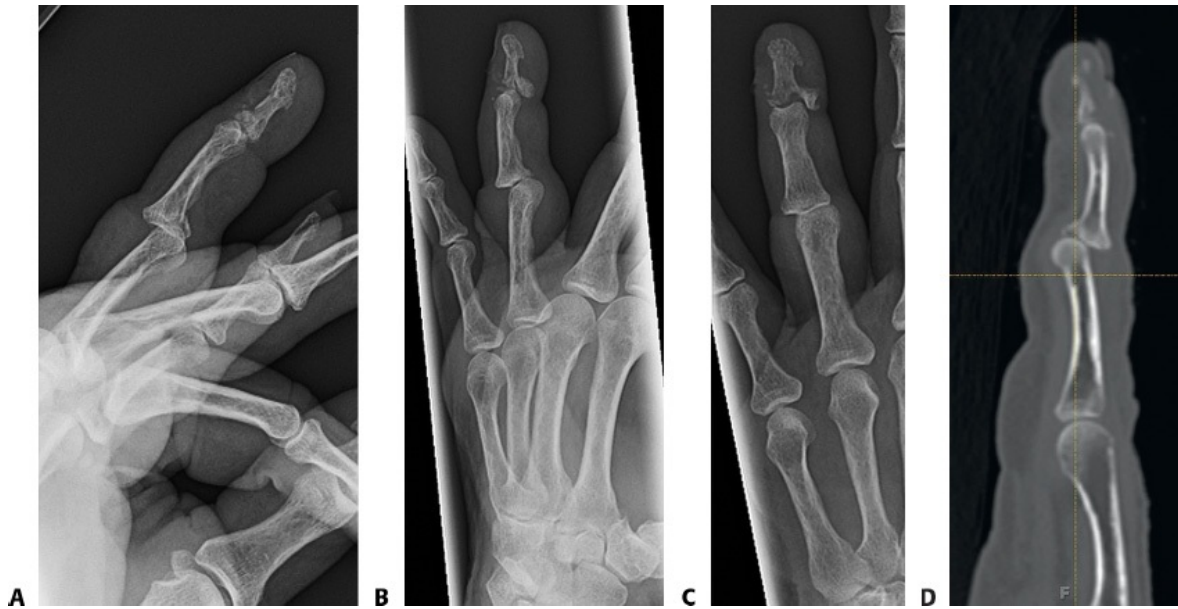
• A–C. Radiographs of the left ring finger demonstrate a fracture-dislocation of the PIP joint with dorsal subluxation. There is also a displaced intra-articular fracture of the distal phalanx. D. A CT scan of the affected digit can be obtained to evaluate the size and number of bony fragments involving the middle phalanx.
